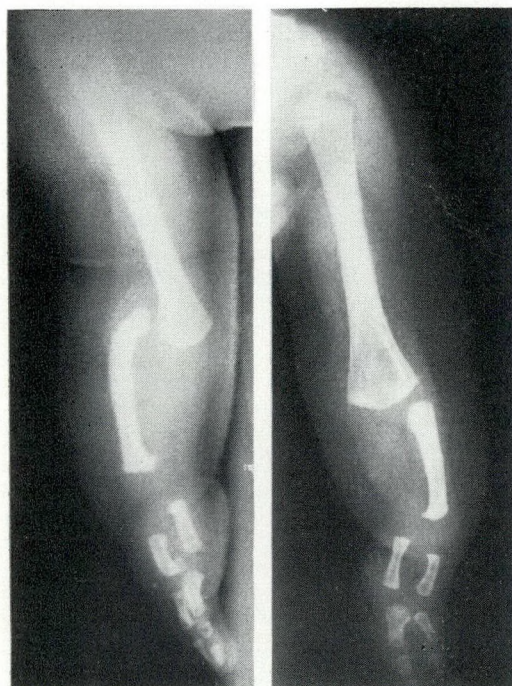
Radiographs at six weeks of age: Bilateral absence of ulna may be confused with congenital absence of radius. Radiographic pictures show: (1) Bilateral complete absence of ulna; (2) Proximal dislocation of head of radius (right); (3) Radiohumeral synostosis (left); (4) Defect on the ulnar side of both hands.
